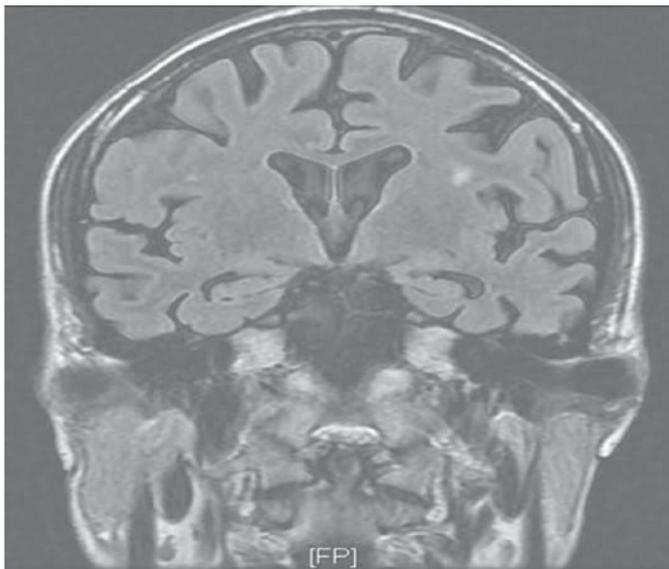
Magnetic resonance imaging scan of brain showing atrophy of hippocampus.
